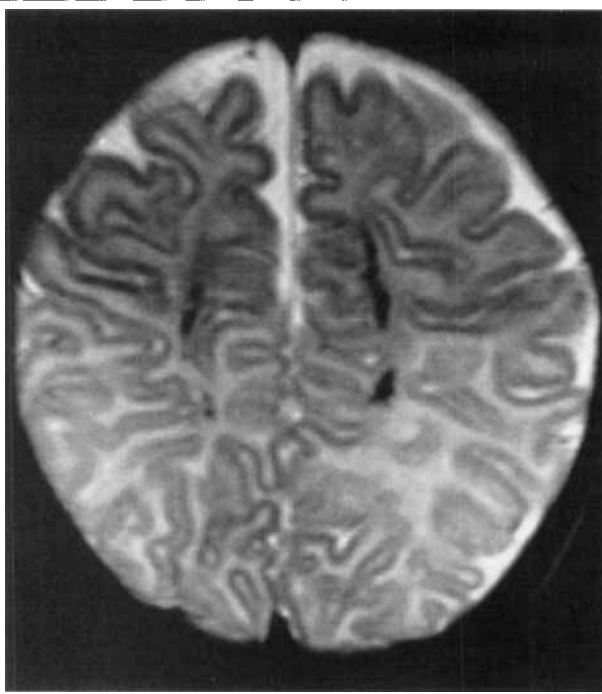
Axial T2-weighted slice acquired near the vertex, returning T2 dark signal consistent with hemosiderin deposition in the centra semiovale overlying the bodies of the lateral ventricles, secondary to prior hemorrhage in the periventricular white matter.
